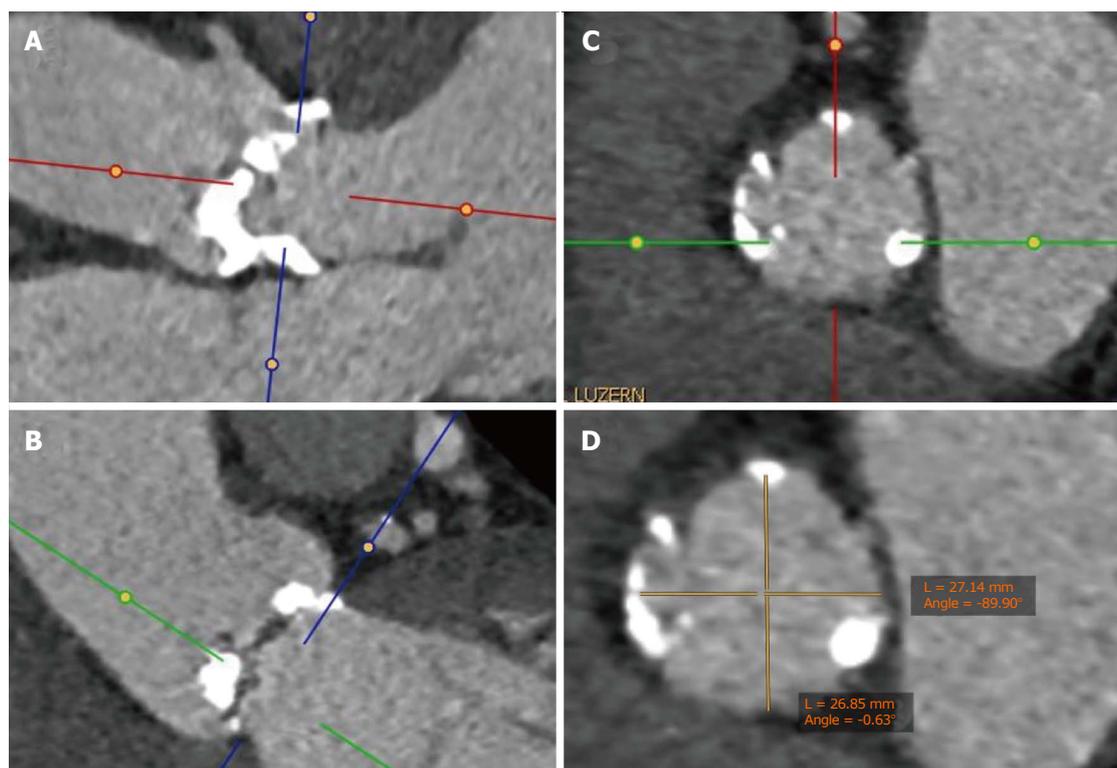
Example of a multiplanar reconstruction of the aortic annulus. A and B: Double-oblique MSCT images at the basal insertion of the calcified native cusps; C: Double-oblique reconstruction at the level of the aortic annulus. The aortic valve leaflets are just barely visible at the level of the ventriculoarterial junction; D: Measurement of the short and long diameter at the level of the aortic annulus. MSCT: Multislice computed tomography.
